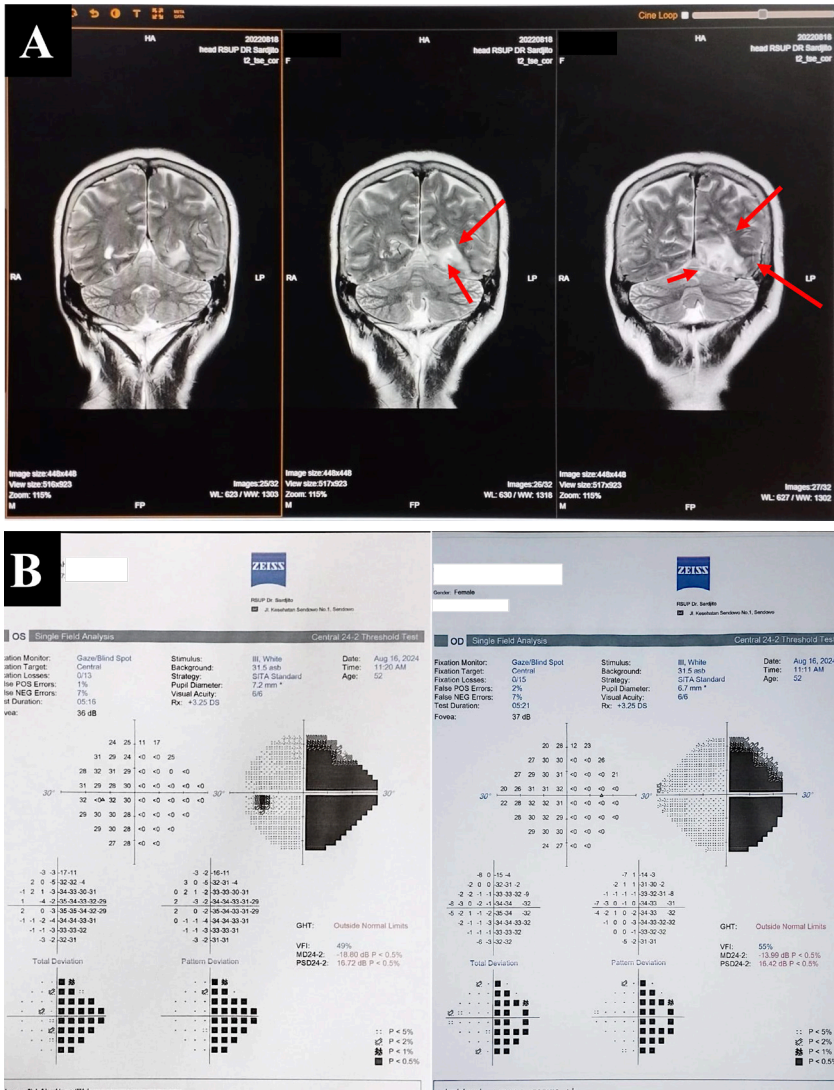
(A) MRI shows acute infarcts on the left occipital lobe. (B) Automated static perimetry shows right homonymous hemianopia.
